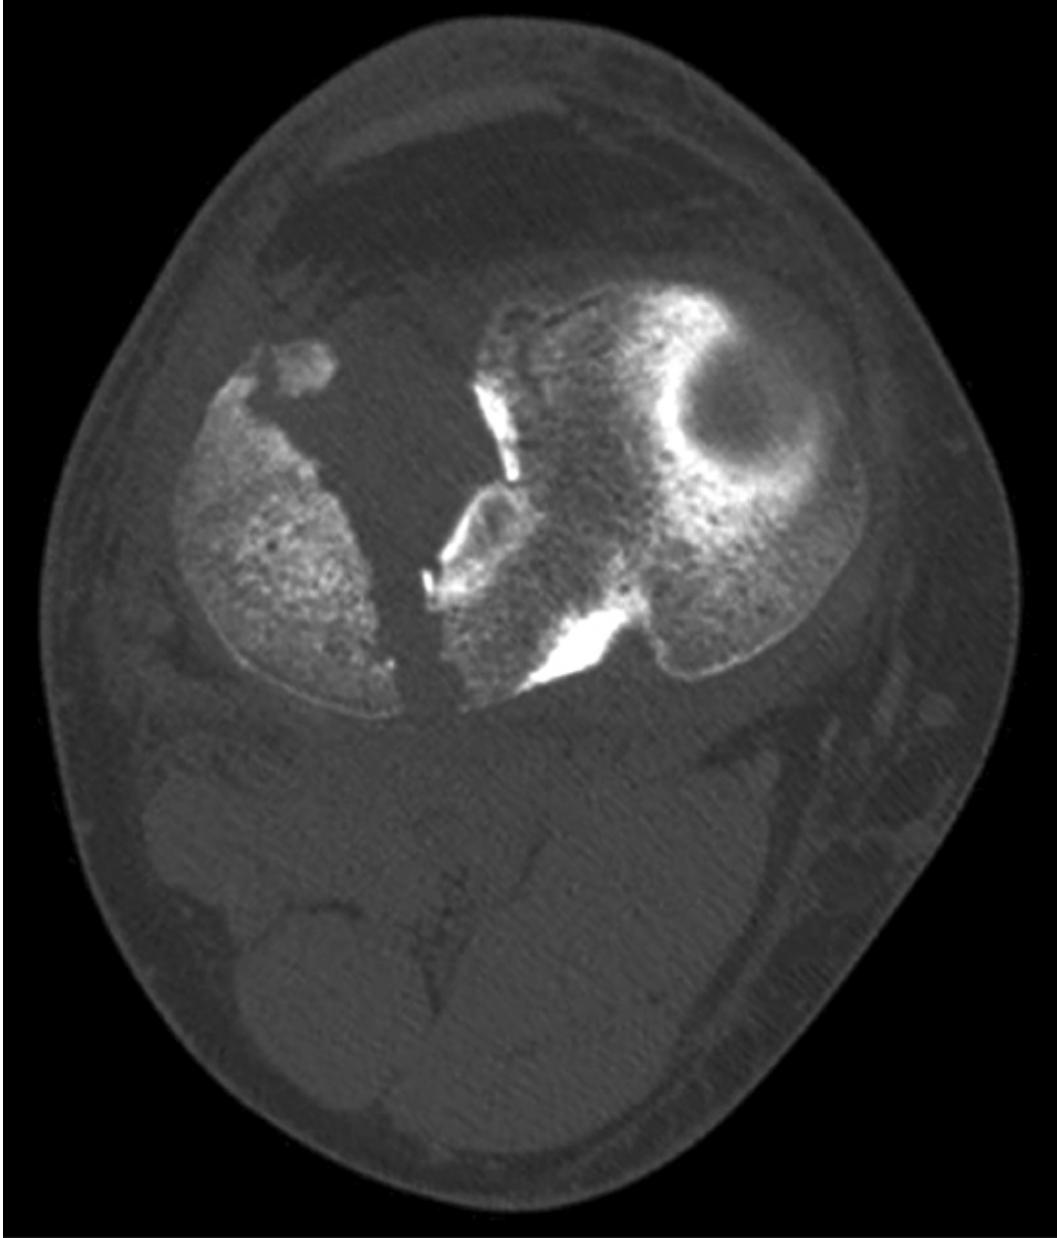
Axial (9), coronal (10), sagittal (11) CT scan images of patient with split depression lateral plateau fracture.
